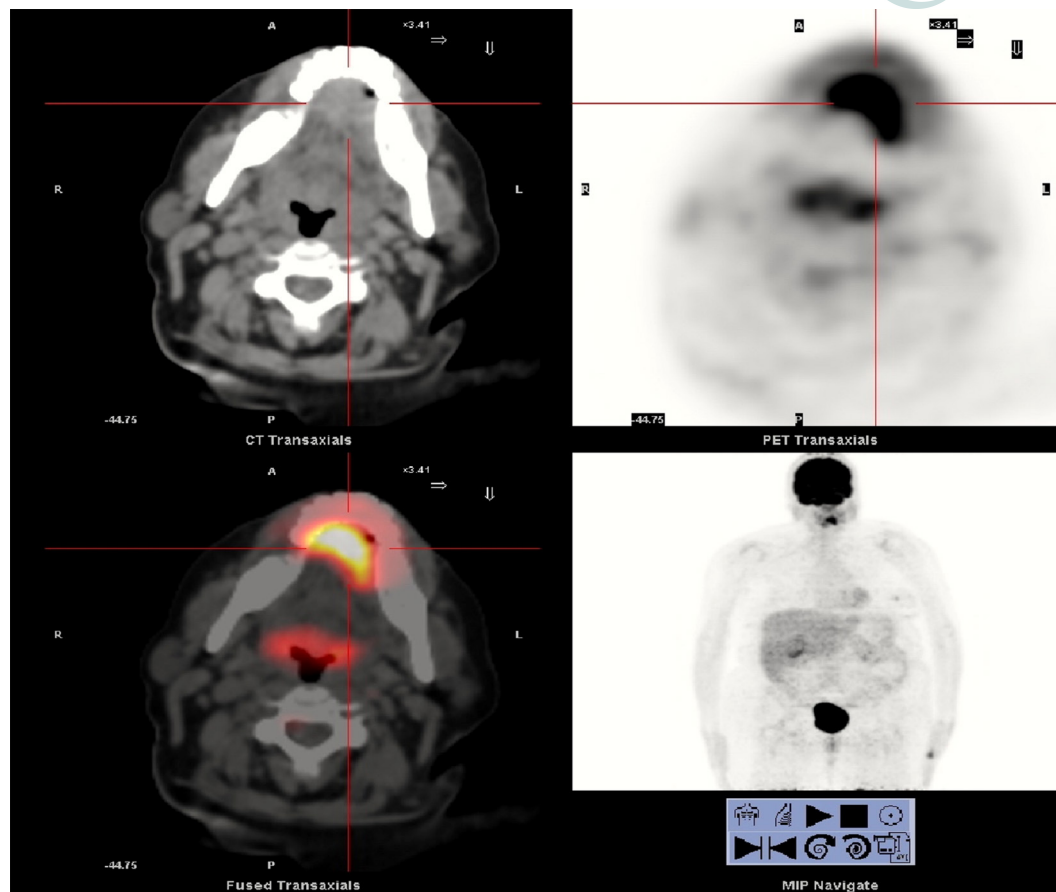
Positron emission tomography-computed tomography shows a mass in the left region of the anterior mouth floor, with marked increase glucose metabolism, about 3 cm in diameter and high probability of malignancy. The other cervical structures have normal glucose metabolism, showing no other hypermetabolic neoplastic involvement
